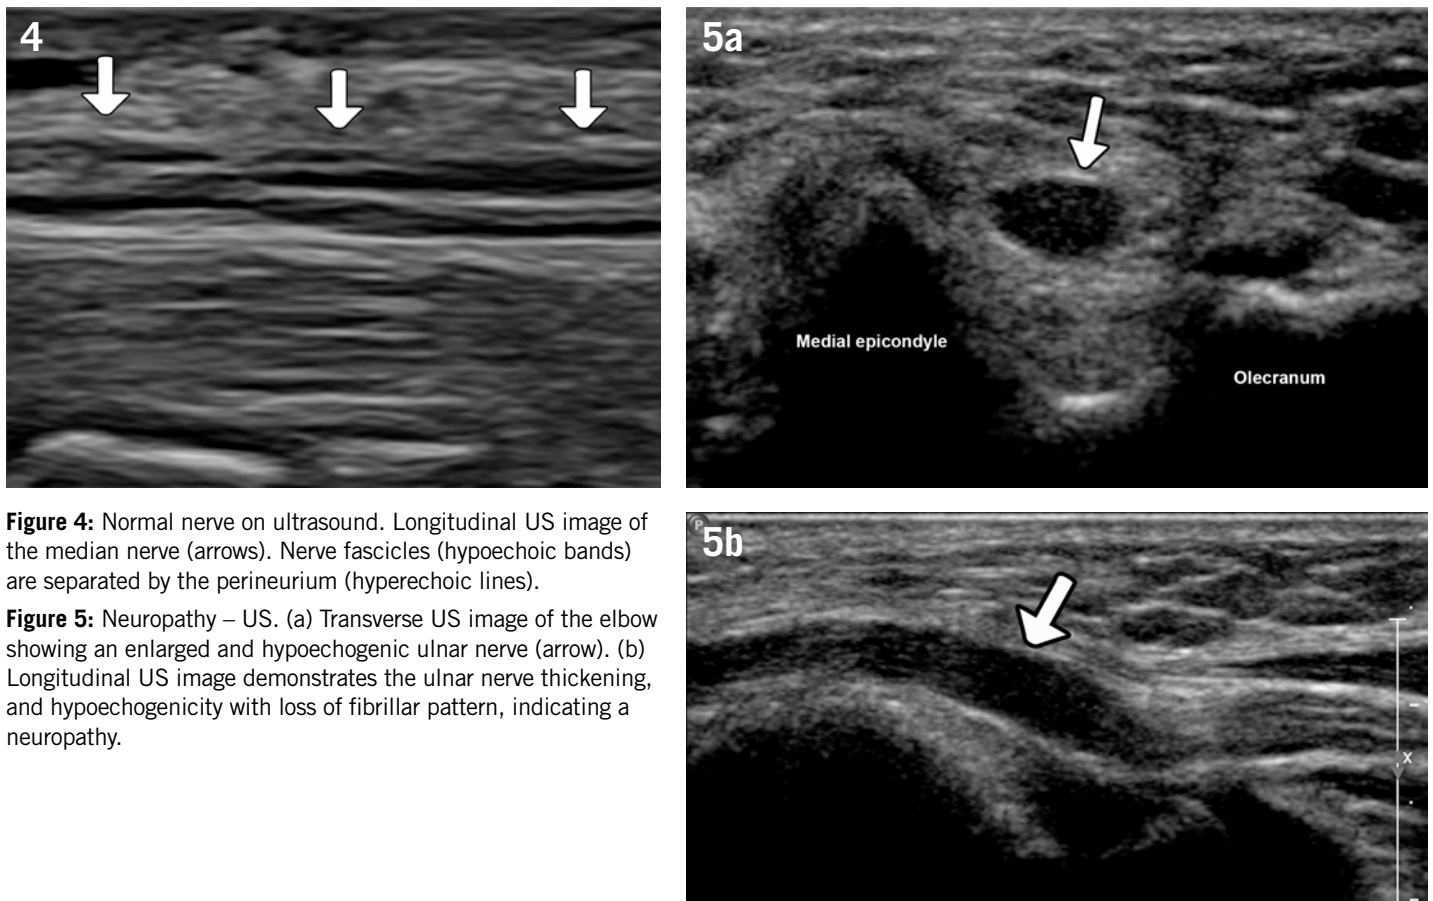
Normal nerve on ultrasound. Longitudinal US image of the median nerve (arrows). Nerve fascicles (hypoechoic bands) are separated by the perineurium (hyperechoic lines).
